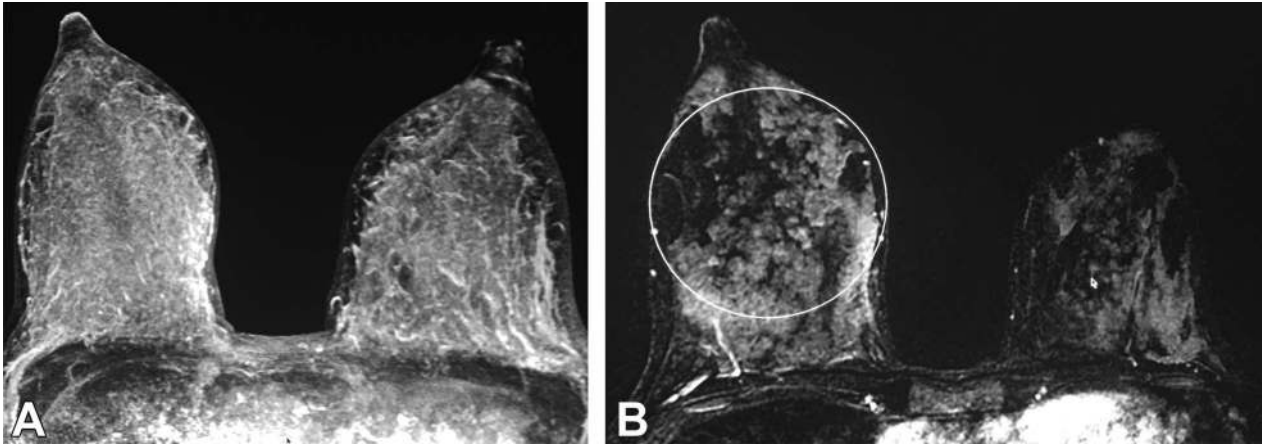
Screening contrast-enhanced breast magnetic resonance imaging examination with normal results of the patient described in Fig. 1B, performed during lactation. A. Postcontrast T1-weighted subtracted maximum intensity projection image demonstrates marked background parenchymal enhancement. B. Postcontrast T-weighted fat-suppressed image showing marked background enhancement with a nodular pattern (circled area, right breast) corresponding to hypertrophic lobules.
